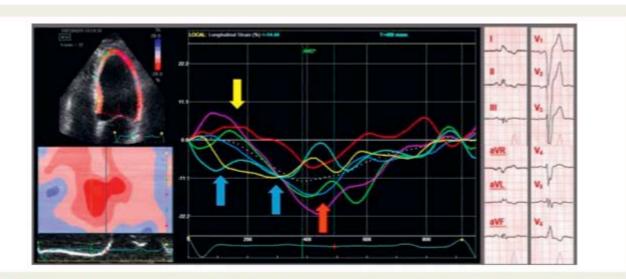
Recording of left ventricular longitudinal strain by speckle-tracking echocardiography in a patient with heart failure and left bundle branch block: there is a characteristic left bundle branch block pattern with early-systolic shortening in the septum (blue arrows), combined with early (pre-stretch) in the lateral wall (yellow arrow), and late peak contraction in the lateral wall (red arrow). AVC, aortic valve closure. Modified from Risum et al.⁶⁸
